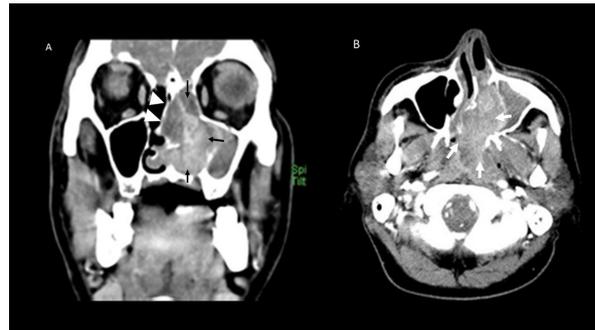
CT paranasal sinus in (A) coronal plane showing a heterogeneously enhancing lobulated mass occupying the left nasal cavity (black arrow) causing expansion of the cavity and right-sided deviation of the nasal septum (arrow head); (B) Axial image of the nasal cavity showing the mass (white arrow) extending into the nasopharynx, obscuring the left posterior nasal choana and nasopharynx.
